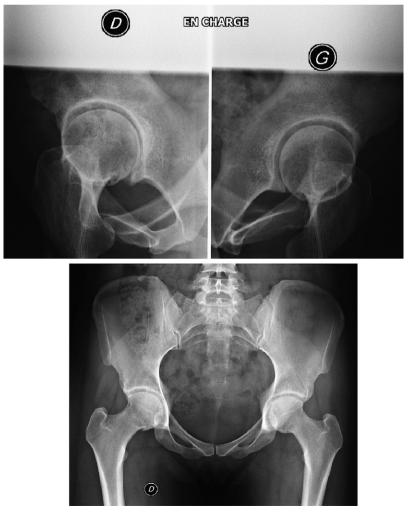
a: radiographs of the hips. Case 1; b: anteroposterior radiograph of the pelvis, standing. Case 1.
